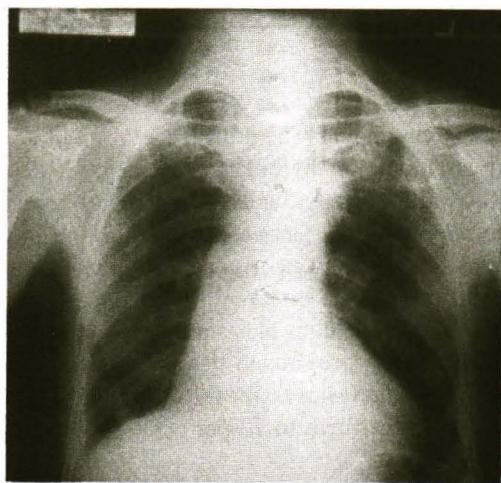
Chest X-ray revealed generalized cardiomegaly with right pleural effusion.
